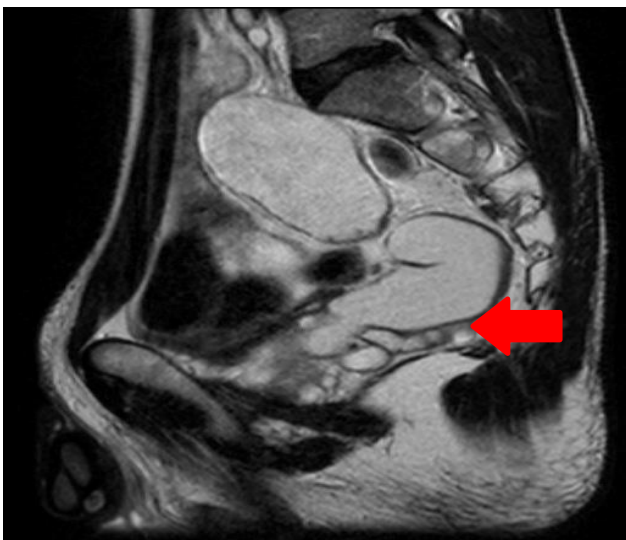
Sagittal section of MRI abdomen and pelvis of the patient showing cystic and tortuous dilatation of the left seminal vesicle with mild to moderate hyperintensity on T2W imaging (marked in red arrow).
